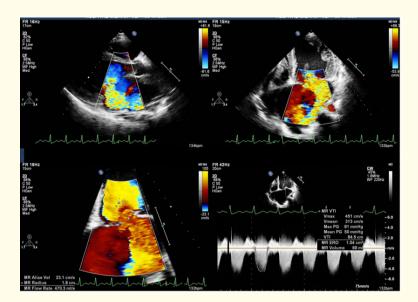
Transthoracic echocardiography showing quantification of severity of mitral regurgitation by two-dimensional Doppler echocardiography.
